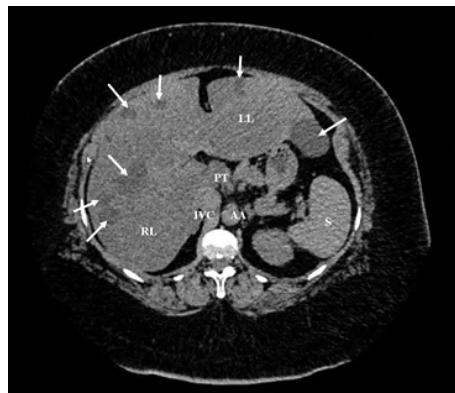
Abdominal CT scan showed multiple liver cysts (arrows) in the right lobe (RL) and left lobe (LL) of the liver. Other structures can be identified in relation to the liver: portal triad (PT), inferior vena cava (IVC), abdominal aorta (AA), and spleen (S).
